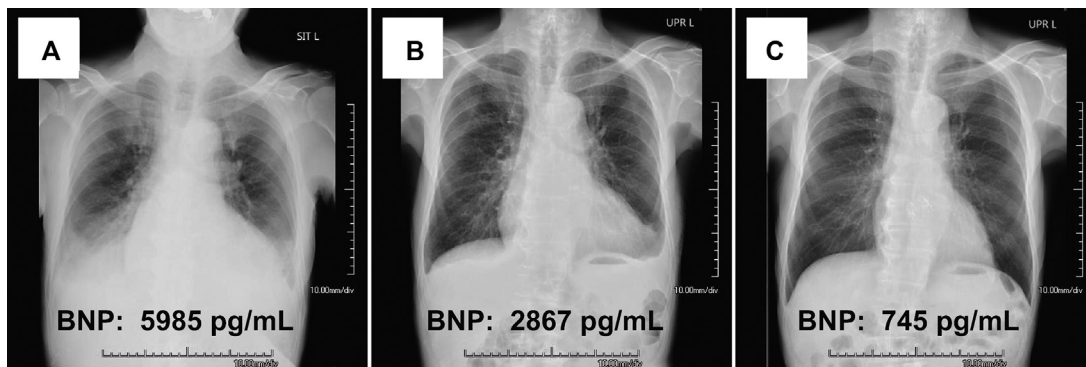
Changes on chest radiographs and in the brain natriuretic peptide (BNP) level. (A) A chest radiograph before balloon aortic valvuloplasty (BAV) showing cardiomegaly, bilateral pleural effusions, and pulmonary congestion. (B) A chest radiograph after BAV showing signs of improvement; no pleural effusion can be observed, but cardiomegaly and pulmonary congestion are still present. (C) The chest radiograph after transcatheter aortic valve implantation shows almost normal findings.
